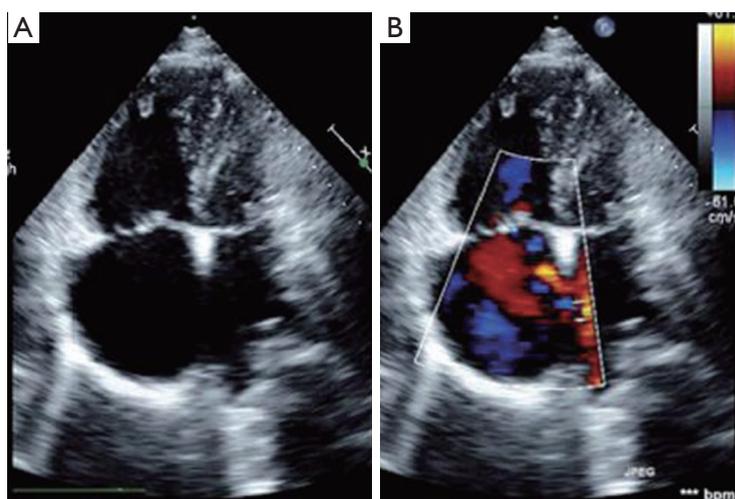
(A) 2D echocardiographic apical view showing a large ASD; and (B) a colour flow mapping demonstrating shunt across. Adapted with permission from Arora *et al.* (16). 2D, two-dimension; ASD, atrial septal defect.
